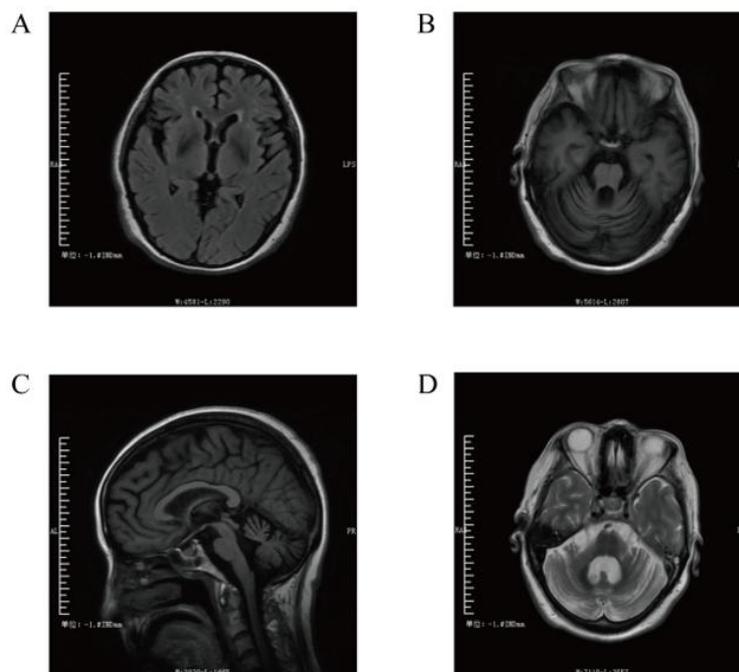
Brain MRI findings consistent with multiple system atrophy : (A) Magnetic resonance images show atrophy of the cerebral cortex with frontal lobe and temporal lobe. (B) Magnetic resonance images show atrophy is prominent in cerebellum. (C) Magnetic resonance images show atrophy is the basis pons, medulla and cerebellum. (D) Magnetic resonance image showing the “hot cross bun” sign.
